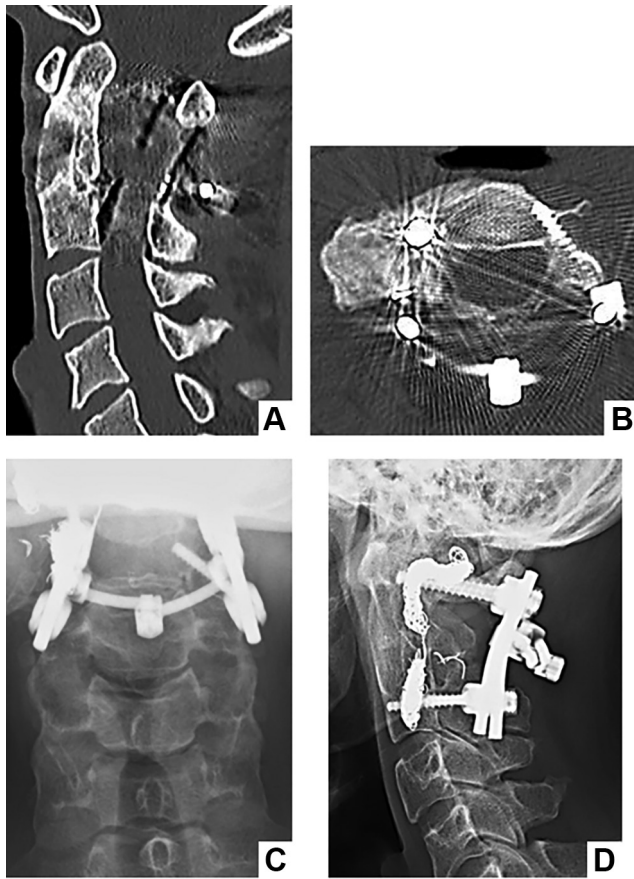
Postoperative and long-term follow-up imaging. A, B) Computed tomography images taken two years postoperatively showed that the grafted bone had fused, and there was no evidence of osteolysis to suggest recurrence. C, D) Radiographs showing no recurrence 10 years postoperatively.
